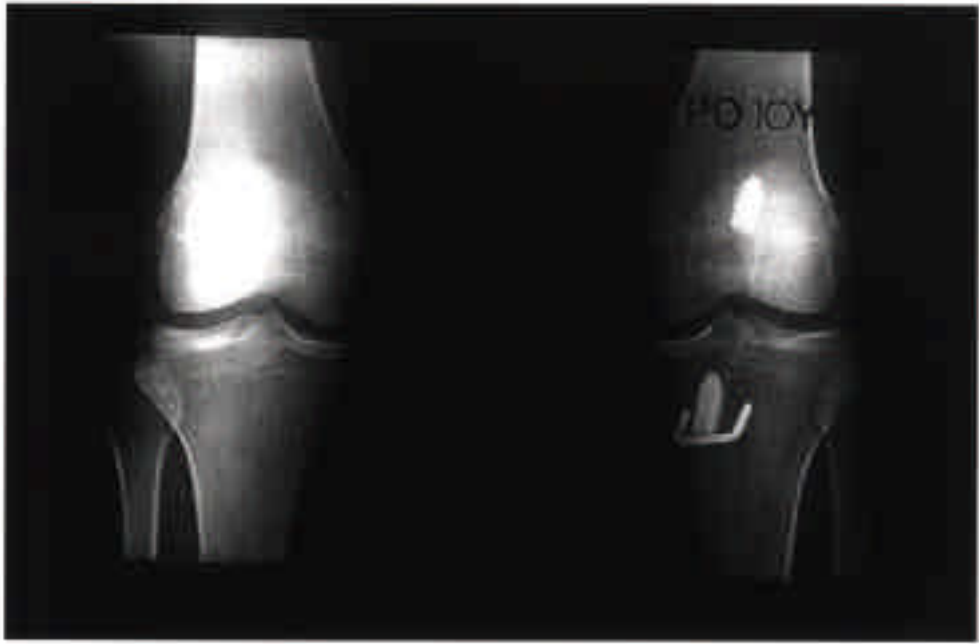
Anteroposterior radiograph of the both knee, taken ten years postoperatively, showing a no arthritic changes of the both knee joints.
